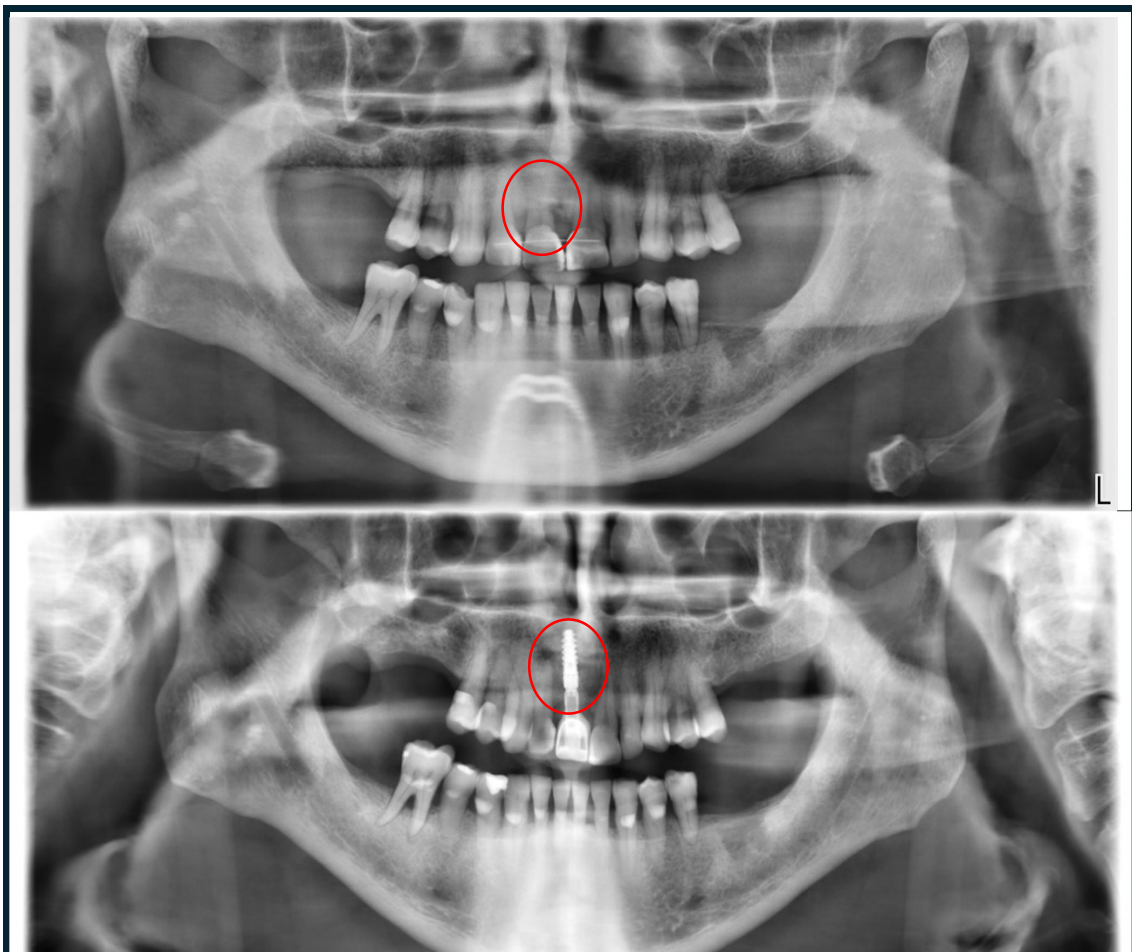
Patient SP1, orthopantomography comparison time 1 16/03/2021 (above), time 2 14/06/2024 (below)
